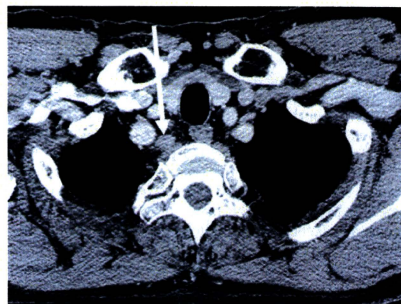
A 57-year-old man with mediastinal lymph node recurrence after potentially curative resection of adenocarcinoma. Contrast-enhanced CT performed 10 months after surgical resection showed a right upper paratracheal node (arrow). The short axis diameter was 8 mm. CT, computed tomography.
